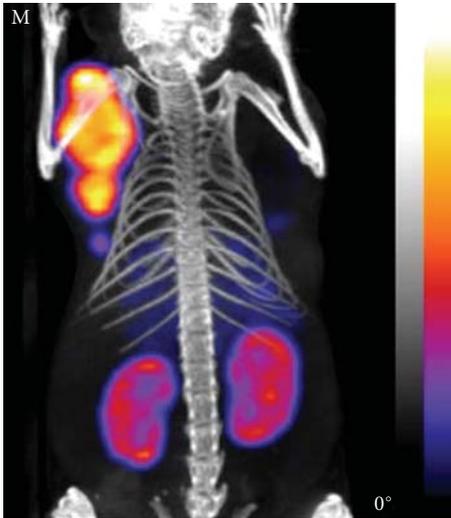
Representative NanoSPECT/CT image of 1 compound showing the tumour and kidney uptake at 4 hours after injection.
